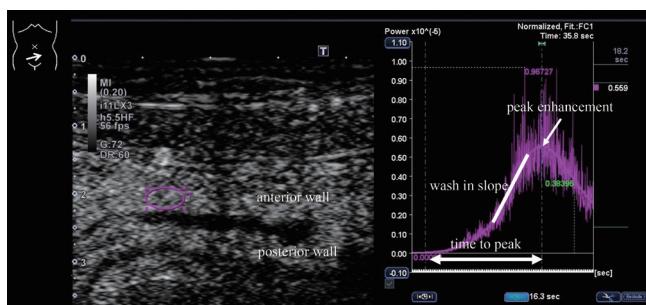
Contrast ultrasound of a lesion of Crohn's disease.
